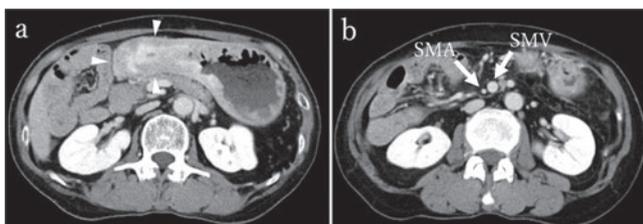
Computed tomography (CT) scan findings before treatment.
